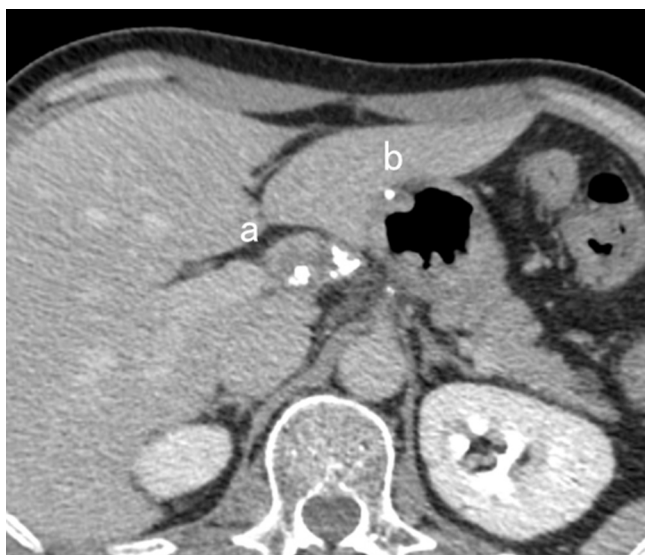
Abdominal computed tomography: (a) calcified lymph node mass in the hepatic hilum; (b) surgical staple of previous gastric surgery.
